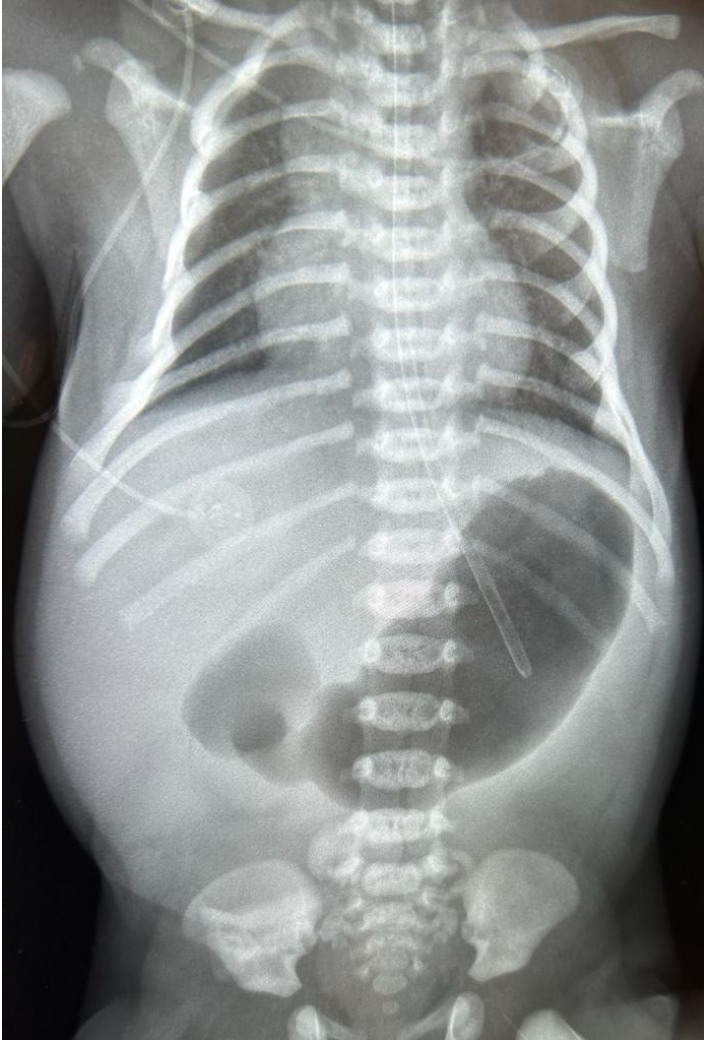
Abdominal X-ray for Annular Pancreas.
